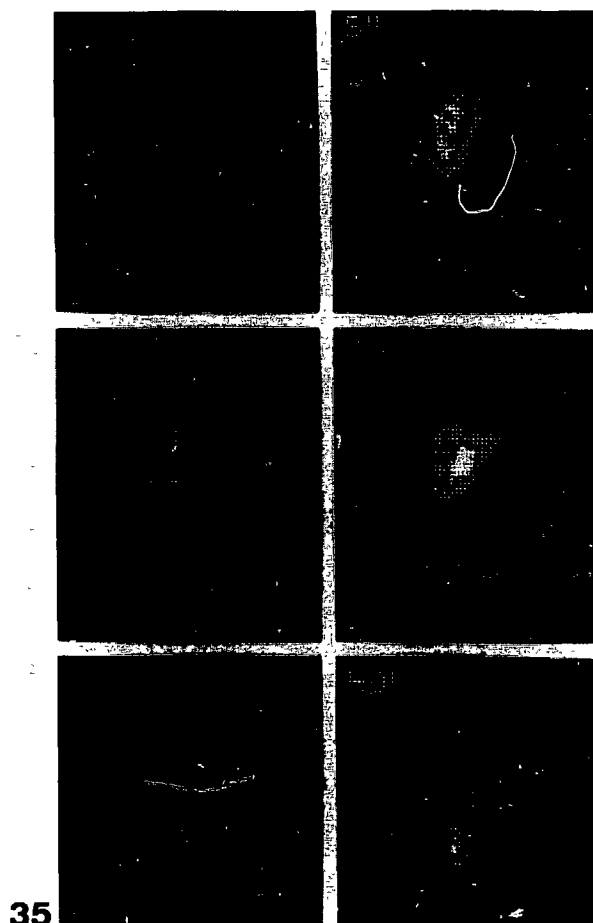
35 Computer display of the serial scintigram of the patient from fig. 13:34 after performing cholecysto-jejunostomy.
